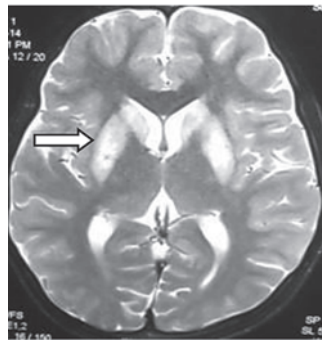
Wilson disease Axial T2 MR image shows hyperintense caudate and putamen
